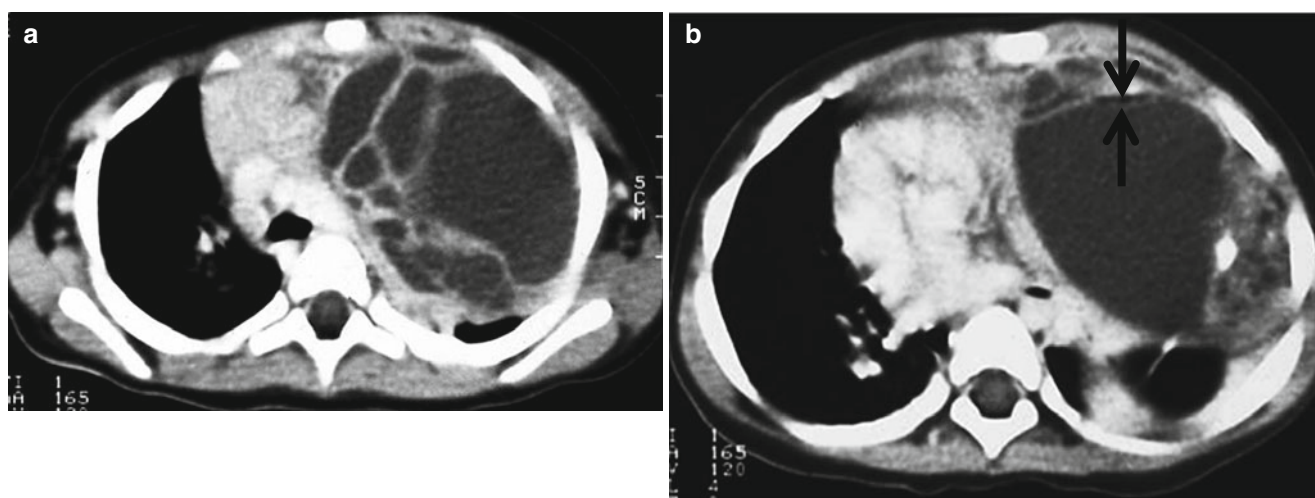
Mature teratoma in a 13-month-old girl with respiratory distress. (a, b) Contrast-enhanced CT shows a large, complex anterior mediastinal mass containing areas of fluid, fat, (*arrows*) and calcification
